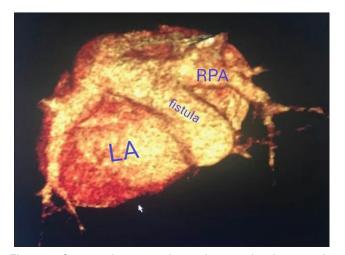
Computed tomography angiogram showing superior view of the heart showing dilated right pulmonary artery and its fistulous connection to the left atrium
